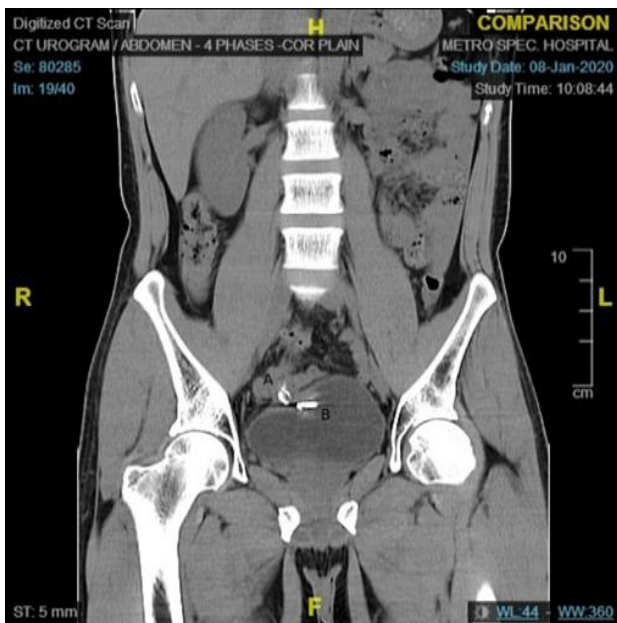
CT urogram of the patient shows foreign body in a bowel loop (A) with previous surgical clip applied during cystoscopy (B).
